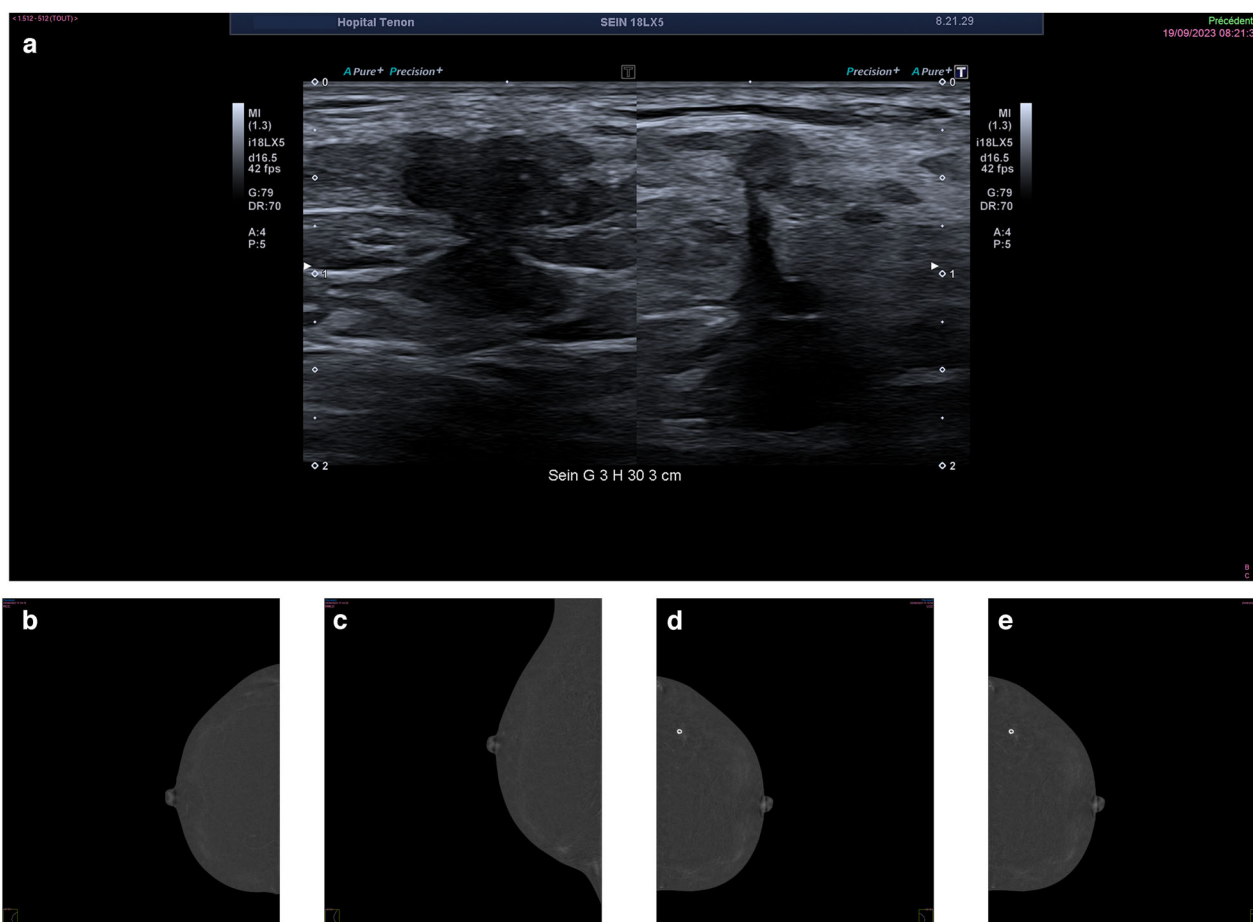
This cancer was difficult to diagnose on imaging (both MG and CEM mammo) but easily detected by clinical examination and ultrasonography. a Ultrasonography. b, c, d, e Contrast-enhanced mammography (RCC, LCC, RMLO, LMLO views)
